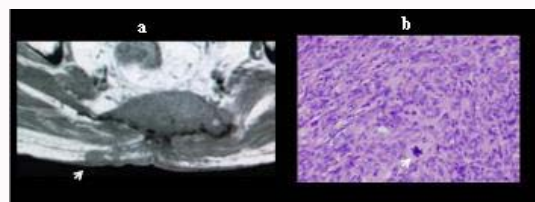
a: A T1-weighted image on MRI examination demonstrated a subcutaneous tumor having a diameter of 1.5 cm (white arrow). b: Resectional biopsy was performed. A high-grade pleomorphic sarcoma with atypical mitosis is present (white arrow). (white bar, 50µm).
